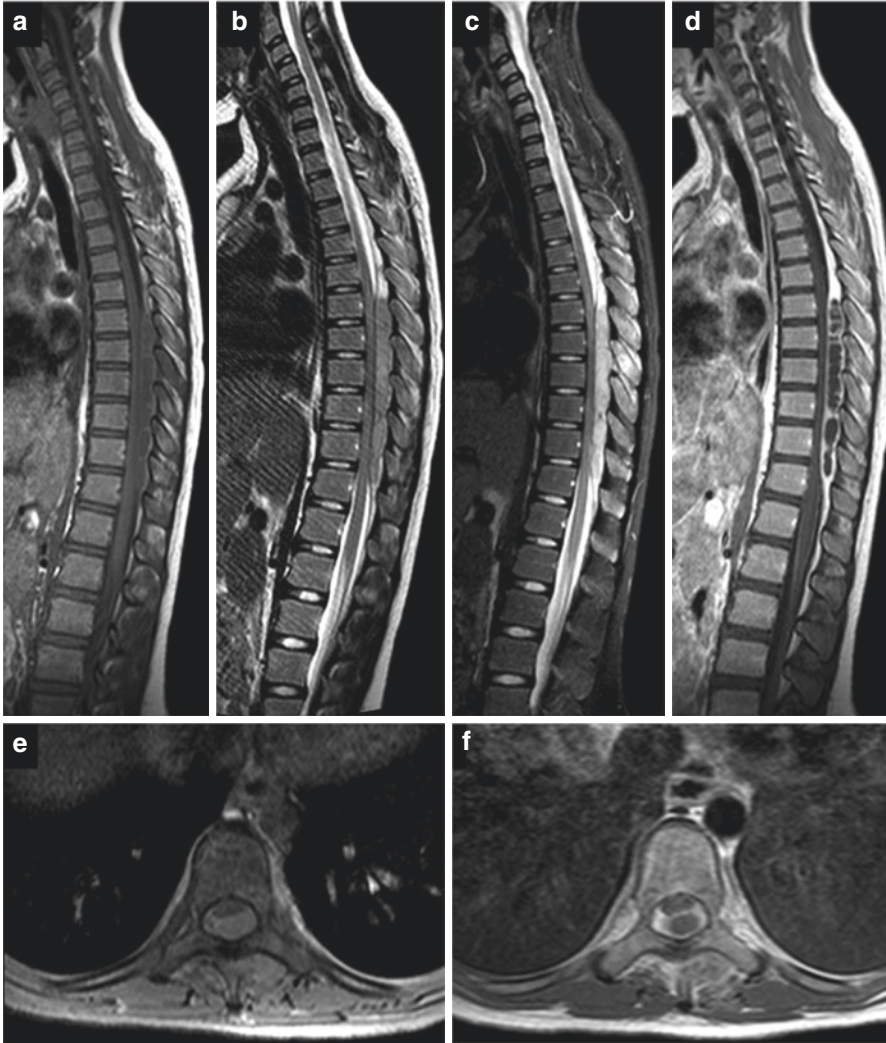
MR appearance of epidural abscess/empyema. T1-weighted (a), T2-weighted (b), STIR (c) and GD-enhanced T1-weighted (d) spine images on the sagittal plane; T2-weighted (e) and GD-enhanced Fat-suppressed T1-weighted (f) spine images on the axial plane. MRI shows extensive dorsal epidural collection at the thoracic spine; the thecal sac is markedly compressed with significant mass effect on thoracic cord: Contrast-enhanced images outline the multiloculated necrotic collection with peripheral enhancement
